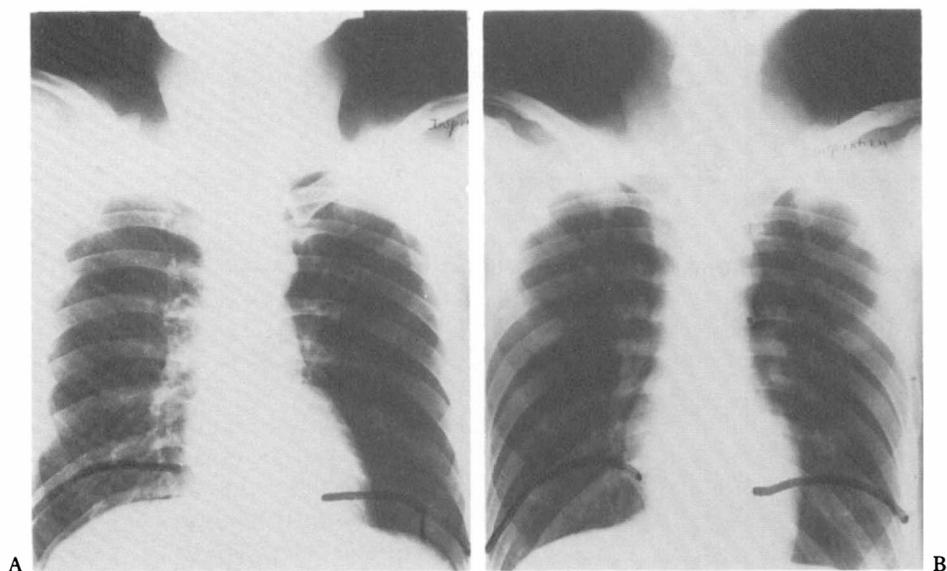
The inspiratory and expiratory roentgenograms of a C7 quadriplegic subject demonstrated the diaphragmatic excursion in supine was larger than that in seated position. (A: seated position, inspiratory phase; B: supine position, inspiratory phase) The solid lines in the films represent the level of diaphragm during maximal expiration.
